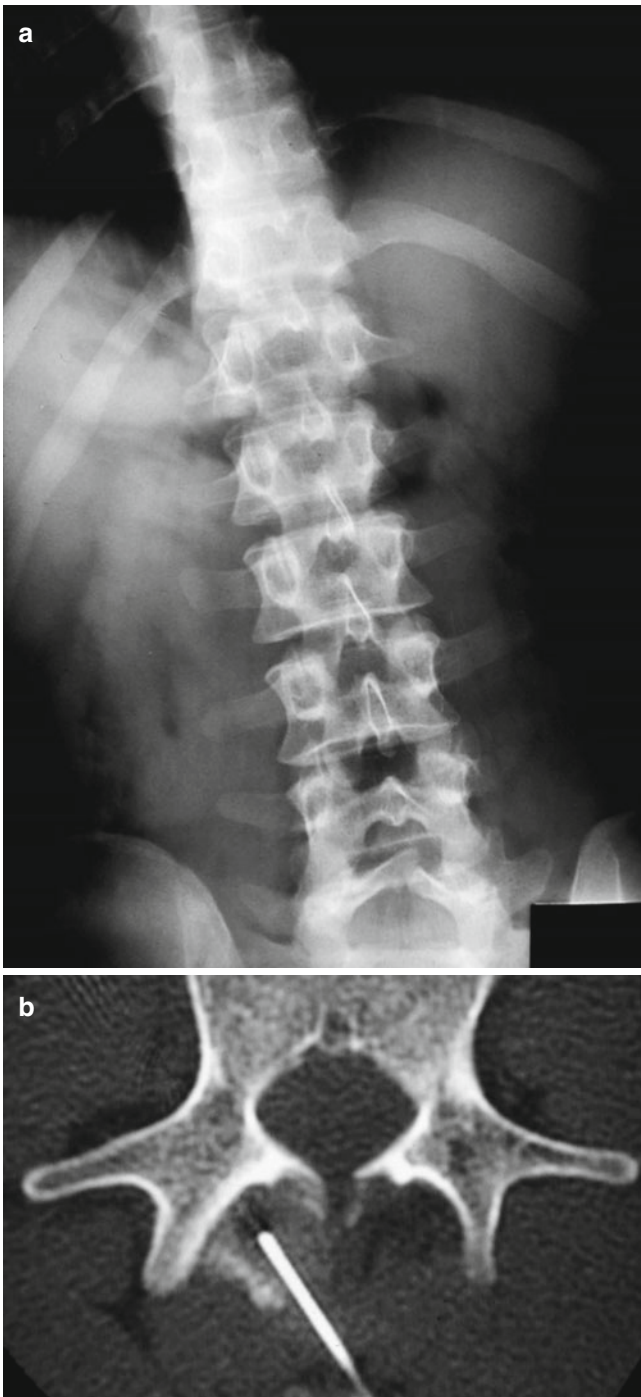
(a) Scoliosis similar to that of osteoma osteoid is seen in osteoblastoma due to unilateral spasticity of spinal muscles. (b) CT-guided needle biopsy of lesion
